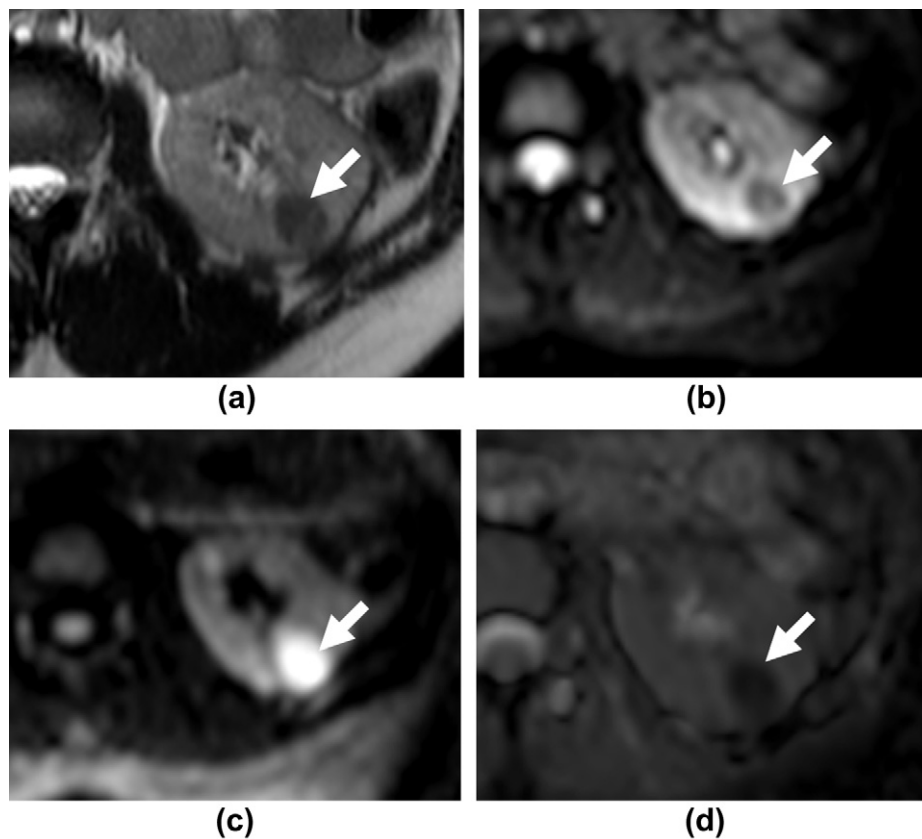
CC RRC in a 73-year-old man. (a) Axial T2-weighted image shows a heterogeneously hyperintense lesion due to some hyperintense areas. (b, c) Axial DWI images with b values of 0 (b) and 1000 (c)  $s/mm^2$ : the lesion is heterogeneously hypointense at  $b_0 s/mm^2$  and heterogeneously hyperintense at  $b 1000 s/mm^2$ . Areas with increase in signal intensity at  $b 1000$  indicate restricted diffusion. (d) Corresponding ADC map shows a heterogeneously hypointense lesion compared with kidney. Lesion ADC is  $1.43 \times 10^{-3} mm^2/s$ . Kidney ADC is  $1.95 \times 10^{-3} mm^2/s$ .
